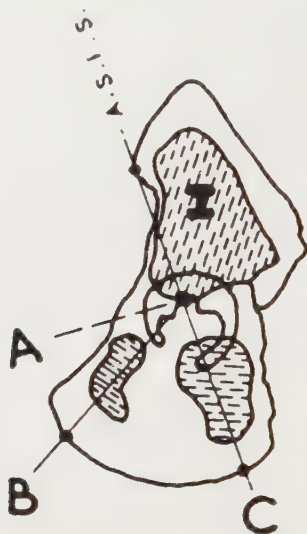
Tracing of the left side of a foetal pelvis with its x-ray superimposed (ossified portion cross hatched). The acetabular labrum is at right angles to the line of vision, showing the location of fixed points A, B and C in the cartilaginous pelvis. A.S.I.S. = anterior superior iliac spine.
